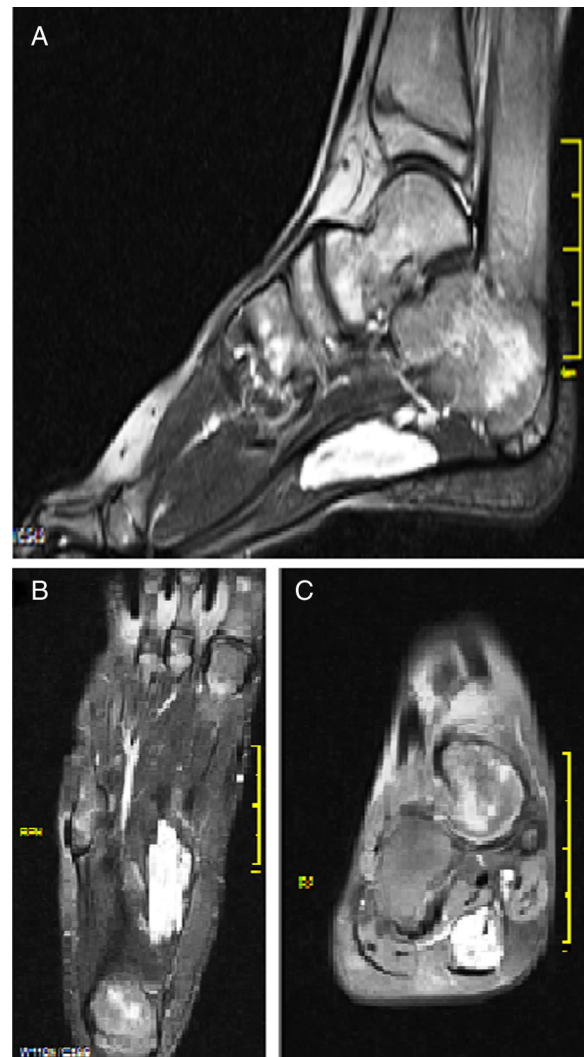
(A) Sagittal plane magnetic resonance image of the intramuscular hemangioma of the right foot for patient 1. (B) Transverse plane magnetic resonance image of the lesion. (C) Frontal plane magnetic resonance image of the lesion.
